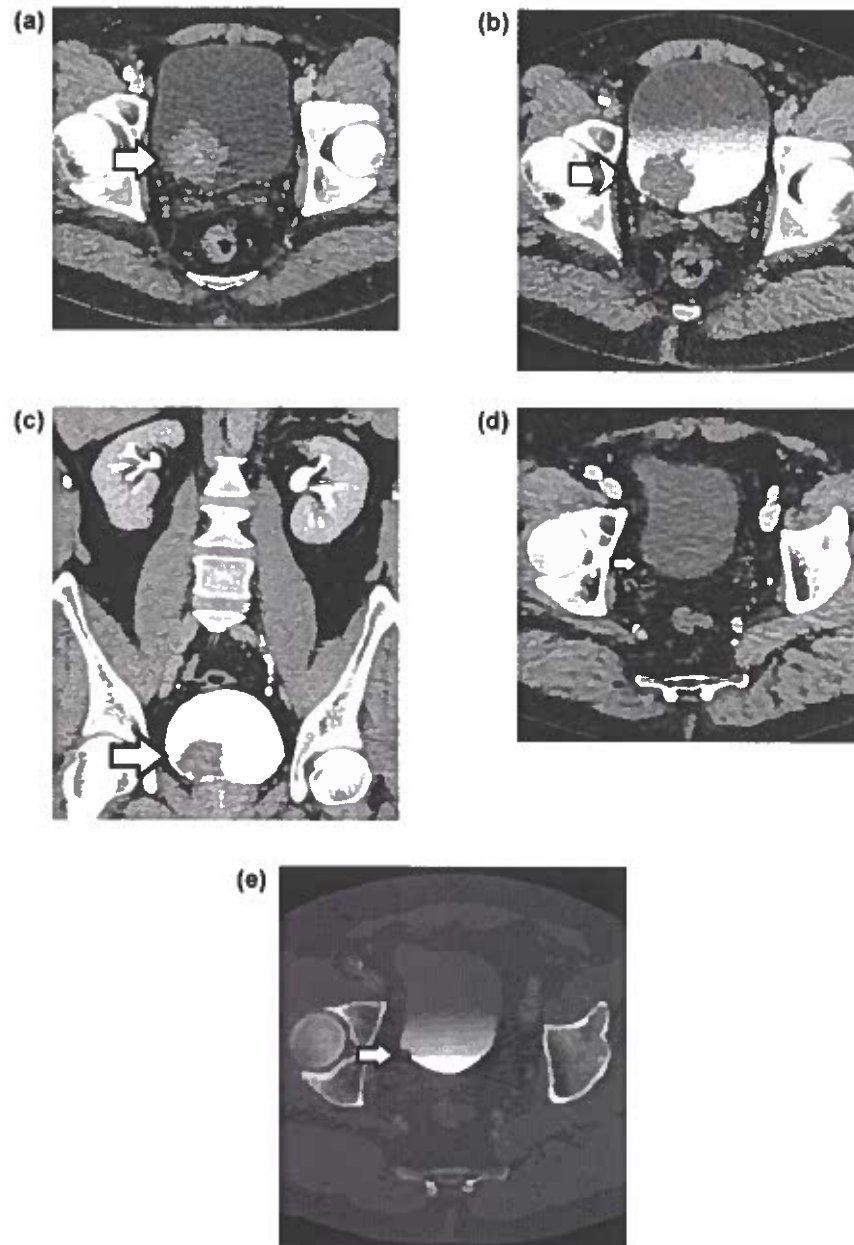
CTU findings of bladder carcinomas in two patients. (a) Axial contrast-enhanced CT reformation during the corticomedullary portal phase, (b) axial and (c) coronal reformations during the excretory phase show a large polypoid tumor (arrow) in the right posterior bladder wall, close to the ipsilateral ureterovesical junction. The mass (arrow) has an irregular surface, enhances heterogeneously and is detected as a filling defect in the excretory phase. Transverse contrast-enhanced reformations during the (d) corticomedullary portal and the (e) excretory phase (wide-window settings) in another patient. A small bladder mass (arrow) is detected in the right posterolateral bladder wall. The tumor is barely seen as a contrast-enhancing lesion in the portal phase, better appreciated as a filling defect in the excretory phase, using bone window settings. Assessment of the excretory phase data with wide window settings is extremely helpful to better visualize small filling defects within the dense excreted contrast medium in the urinary collecting system.
